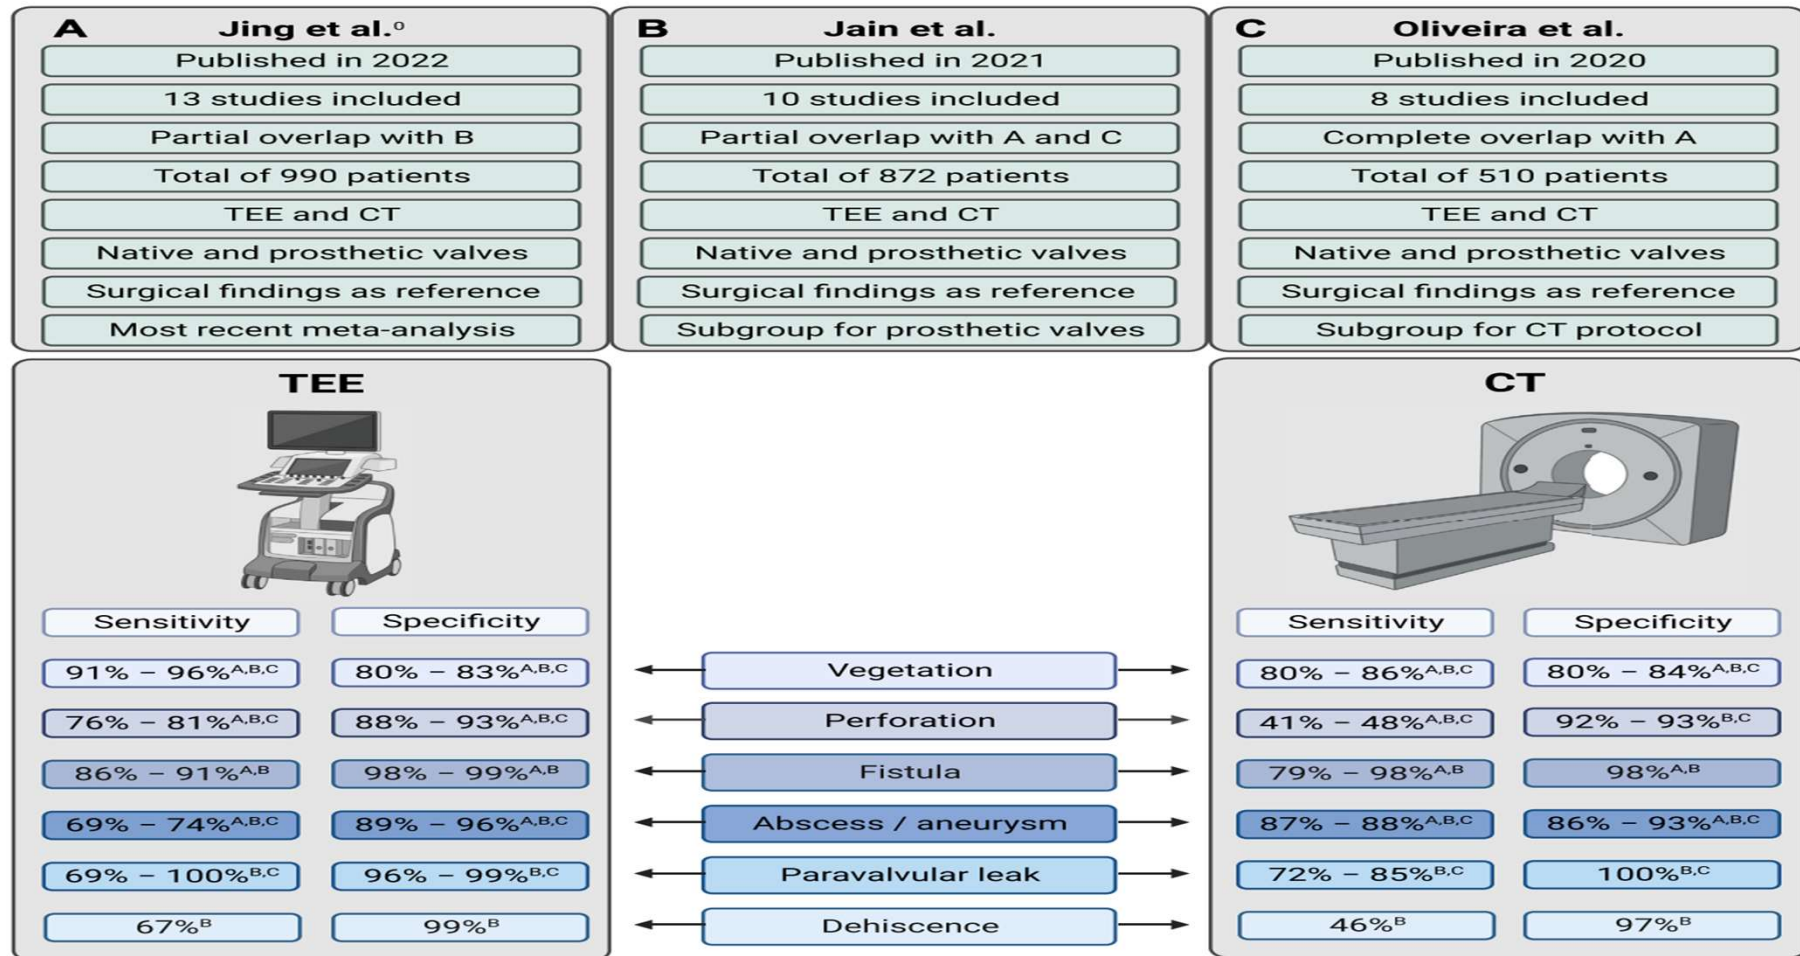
Summary of 3 meta-analyses considering the diagnostic accuracy of transesophageal echocardiography (TEE) and computed tomography (CT) for infective endocarditis. The most important study characteristics are provided and the range of pooled sensitivity and specificity for different signs of endocarditis. (A) Meta-analysis by Jing et al.⁴⁰; (B) meta-analysis by Jain et al.⁸; (C) meta-analysis by Oliveira et al.⁹
